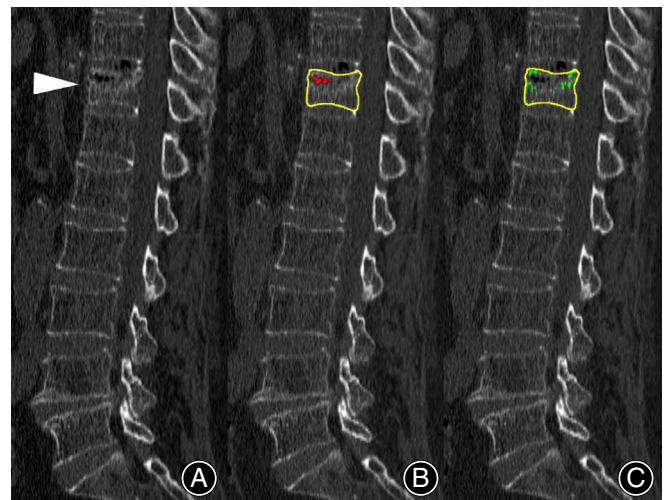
Sagittal lumbar CT image analyzed by ImageJ. The original image of the T11 vertebra (A, arrow) analyzed by ImageJ with a CT value of -1000 HU indicates the IVC filled with gas (B, red color area) in the T11 vertebra (yellow outline). The same original image analyzed by ImageJ with a CT value of 300 – 1000 HU shows no continuous mineralized callus formation (C, green color area) inside or outside of the IVC, indicating the IVC nonunion. HU Hounsfield Unit, IVC intravertebral vacuum cleft
